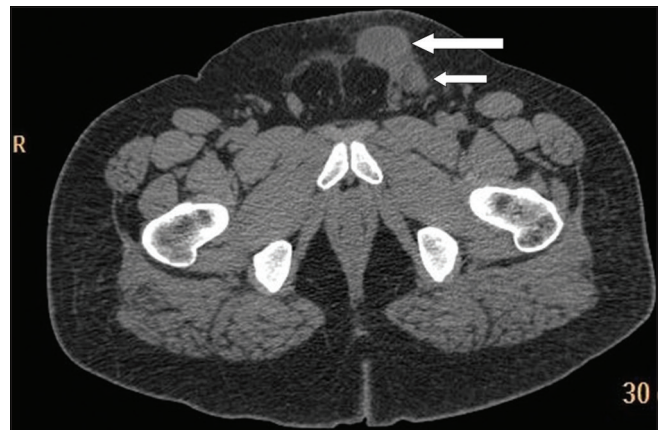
Axial non contrast computed tomography shows cryptorchid left testis in the left inguinal canal (long white arrow) and adjacent proximal soft tissue representing twisted cord (short white arrow)
